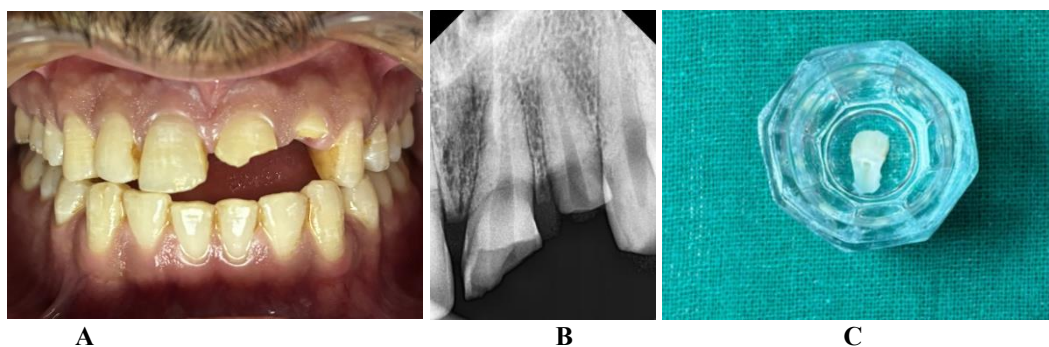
(A) Clinical front view after removal of fractured fragment from 21 and 22 (B) Radiograph after removal of fractured fragment from 21 and 22 (C) Fractured fragment stored in saline in 22
